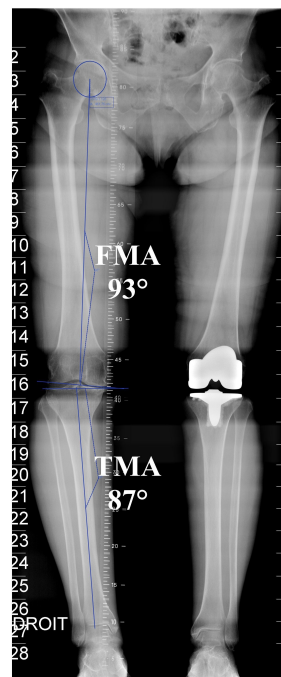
Femorotibial joint line inclination of  $3^\circ$  varus on long leg radiographs
